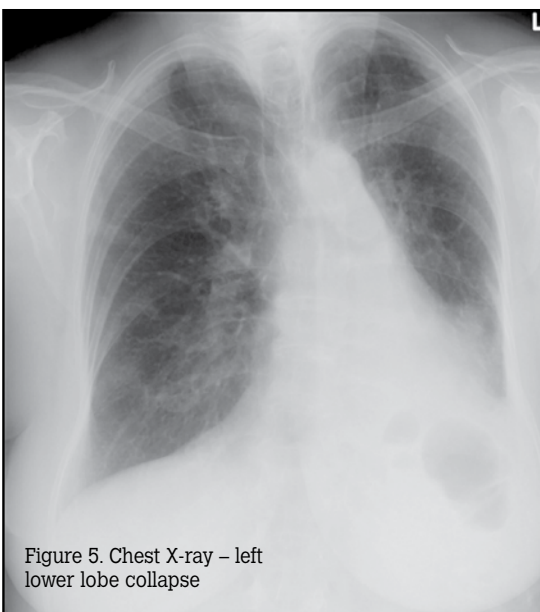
Chest X-ray – left lower lobe collapse
